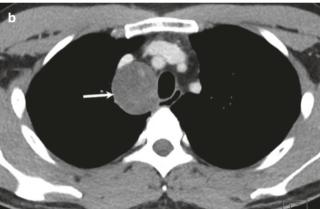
33-year-old man with right paratracheal vagal schwannoma. (a) Frontal radiograph shows a smoothly marginated right paratracheal opacity (arrow) indenting the right lateral wall of the trachea. (b) Axial CT shows a well-circumscribed mass (arrow) in right paratracheal region with mass effect on the trachea
